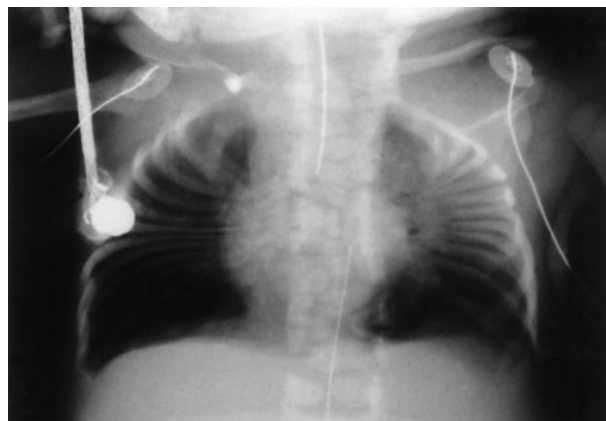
X-ray of infant with spondylothoracic dysplasia (Jarcho–Levin syndrome). Severe abnormality of the spine is apparent with multiple hemivertebrae and the 'crab-like' ribs with close approximation posteriorly and splaying out anteriorly.
